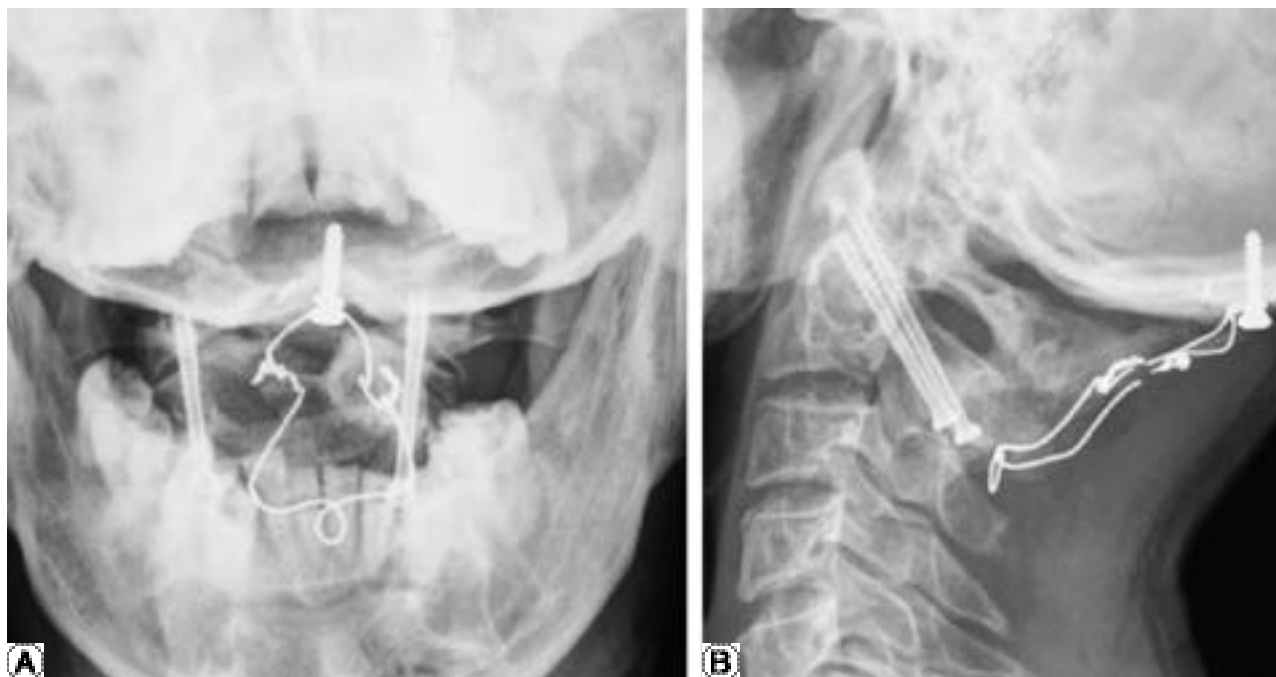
Postoperative (revision C1-2 transarticular screw fixation) one-year follow-up radiography of the cervical spine. Open mouth view shows good reduction of the C1-2 segment and good purchase of C1-2 articulation with screws (A). Lateral radiography of the cervical spine shows good reduction of odontoid process and good bony fusion between the C1-2 segment (B).
